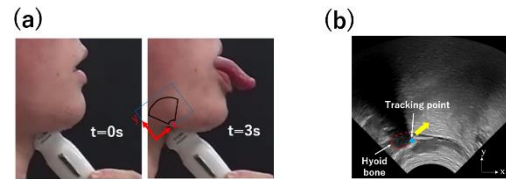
Ultrasound measurements of the hyoid bone (HB) displacement during tongue protrusion, lateral view (a) and an ultrasound image (b).
